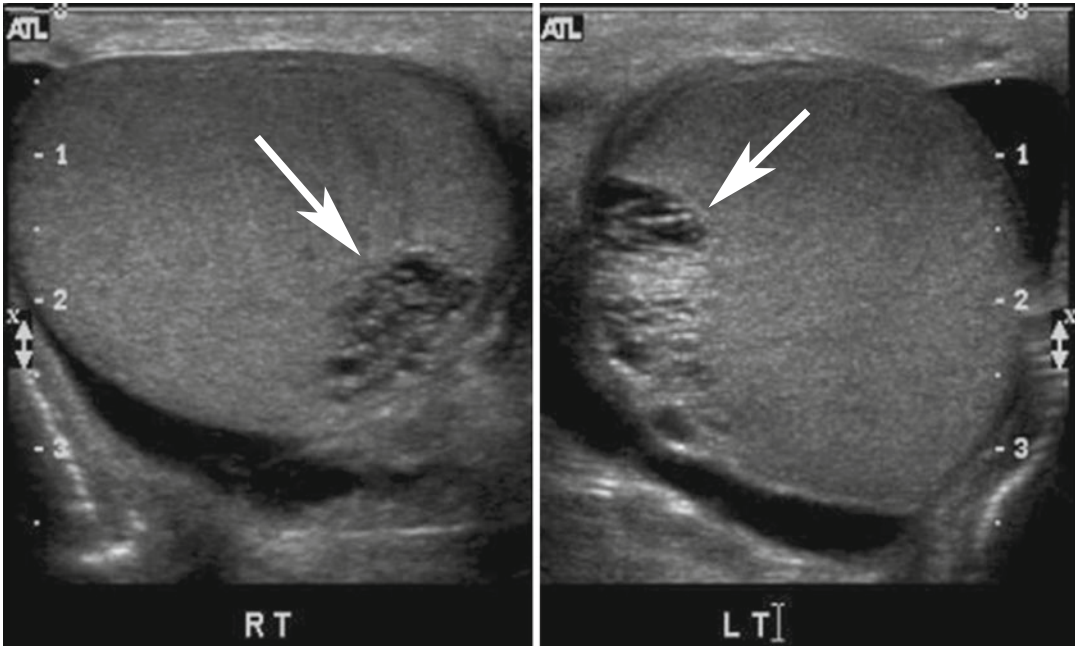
Scrotal ultrasound images of a 68-year-old man show incidental finding of dilated rete testes bilaterally (arrows). These are the typical location and appearance of this benign finding
